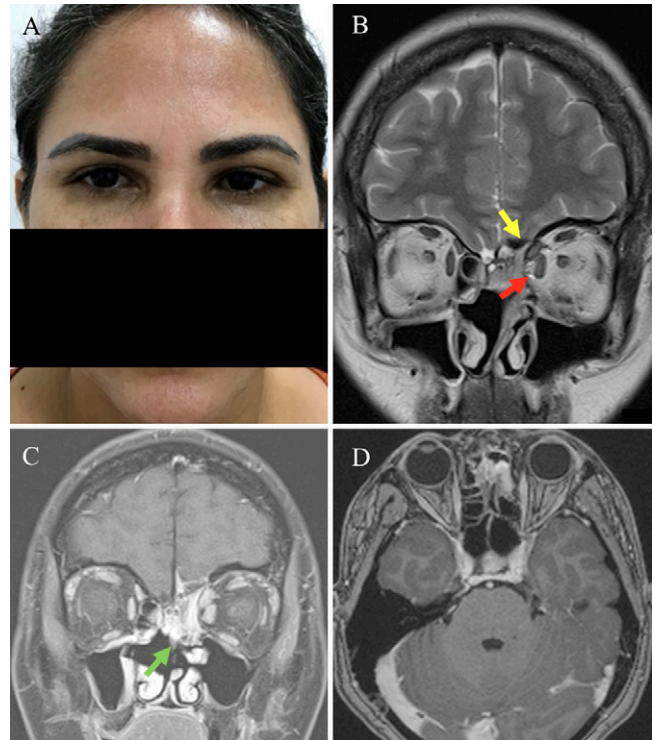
Postoperative photograph (A) showing proptosis recovery. T2-weighted MRI scan (B) shows the normal position of the rectus medialis muscle (red arrow) and superior oblique muscle (yellow arrow). Coronal (C) and axial (D) contrast-enhanced T1-weighted MRI scans show the nasoseptal flap with homogeneous enhancement in the medial wall of the left orbit covering the anterior skull base (green arrow).
